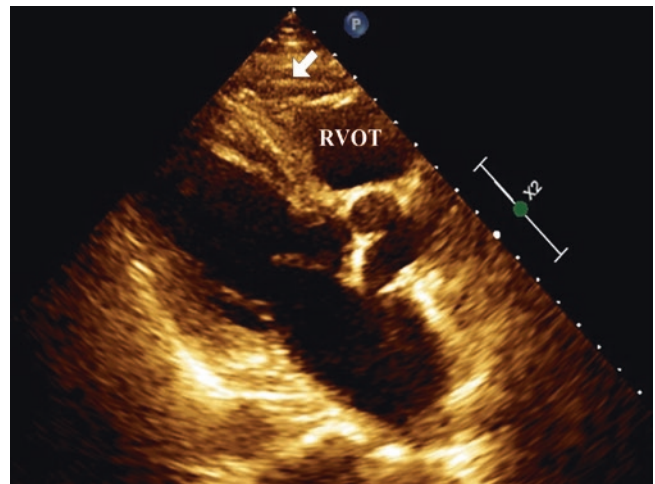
Pericardial fat in the parasternal long axis view. Pericardial fat commonly appears as hypoechoic area overlying the right ventricular outflow tract (RVOT) in the parasternal long axis view. It should not be confused with pericardial effusion. The thin and bright line of the parietal pericardium is seen (*arrow*) separating the anterior pericardial fat from posterior epicardial fat. See also Video 18.5
